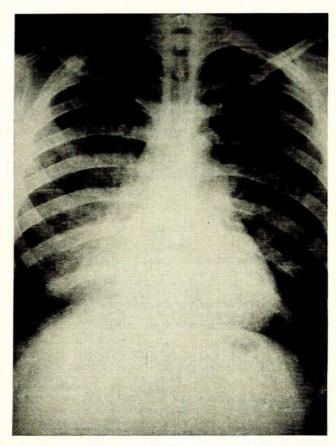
Straight P-A radiograph of the chest, showing diffuse mottled opacities spreading from the hila (right more marked than left). Lesions spread to periphery and are more severe in lower lobes. No cardiomegaly.
